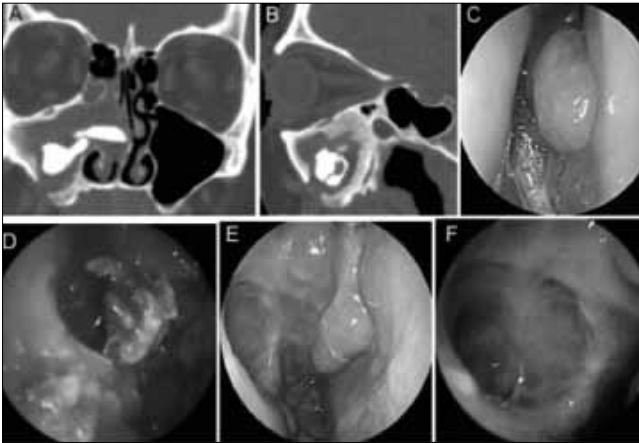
Patient 27. SCDDT as a result of elevation of the maxillary sinus floor with dislocation of grafting material (Class 1a). The patient was treated in 1990 for the elevation of the maxillary sinus floor. In 2007, three dental implants were added to the patient, which later were removed because of infection. The patient referred to us for a swollen cheek and unilateral purulent rhinorrhoea, without symptoms of OAF. She refused any oral procedures, and underwent EES. A, B) Coronal and sagittal CT scans showing filling material within the right maxillary sinus (MS), erosion of the inferior wall of the MS determined by the sinus floor lifting procedure and complete obliteration of both MS and the ostiomeatal complex; C) Purulent secretions in the middle meatal of the right nasal cavity; D) Removal of the grafting material used for sinus floor elevation and ethmoidectomy; E, F) Postoperative nasal endoscopy 5 months after surgery showing the restitutio ad integrum of the MS and the anterior ethmoid. Note the turbino-plasty of the middle turbinate.
